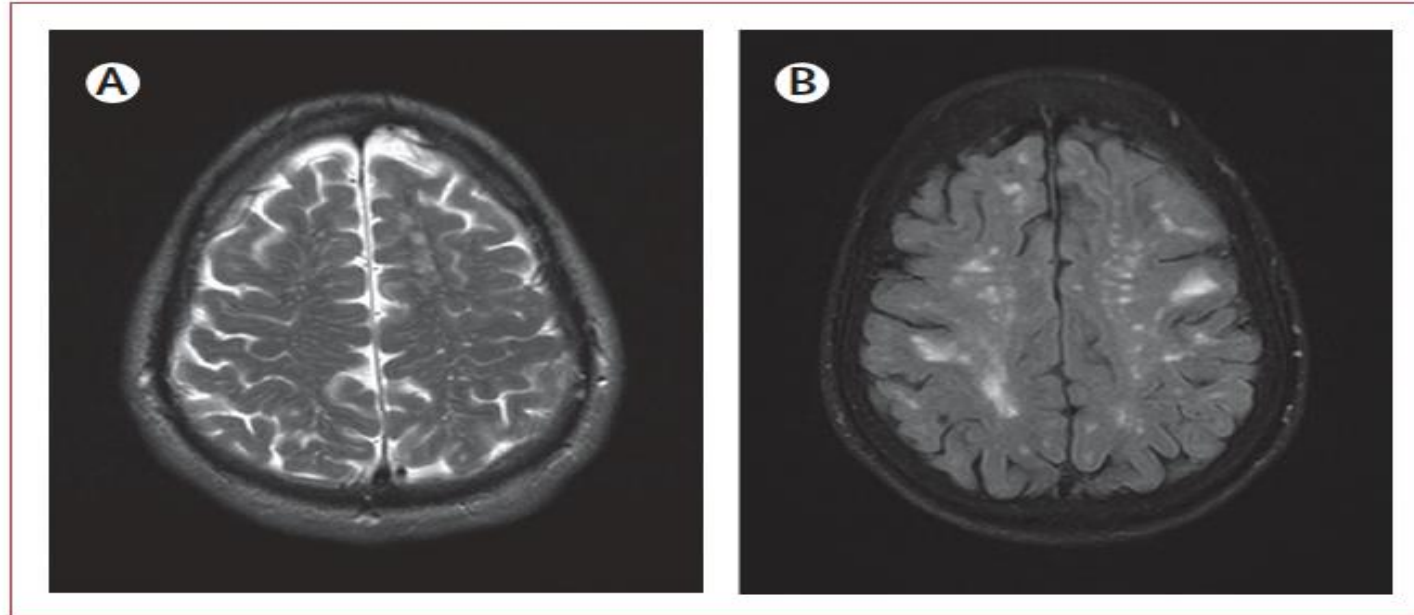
Non-haemorrhagic white matter MRI markers assessed and finally included in the Boston criteria v2.0
